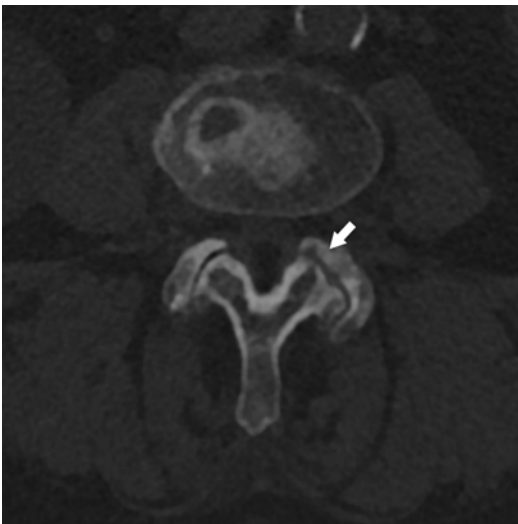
Posterior articulation degenerative disease. Axial CT reformat shows sclerosis of articular facets with osteophytes (*arrow*)
